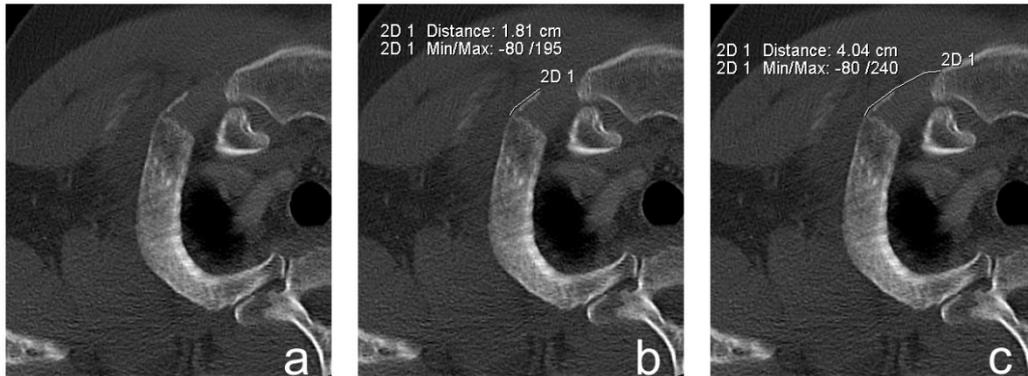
The CT images of the second cartilage stage: a) image without measures, b) OCP.Le, c) CS.Le.
